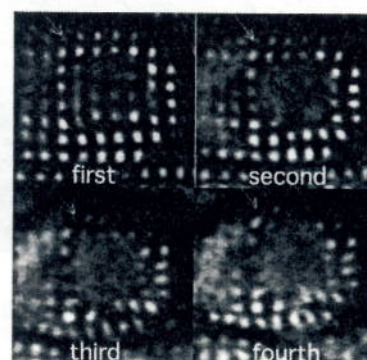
Hibernating myocardium. Serial short axis cine MR images with myocardial tagging using the SPAMM sequence show marked decrease of distortion of the myocardial tags in the anteroseptal wall (arrows). The remainder of the myocardial segments show inward or radial displacement, as well as distortion of the myocardial tags.
